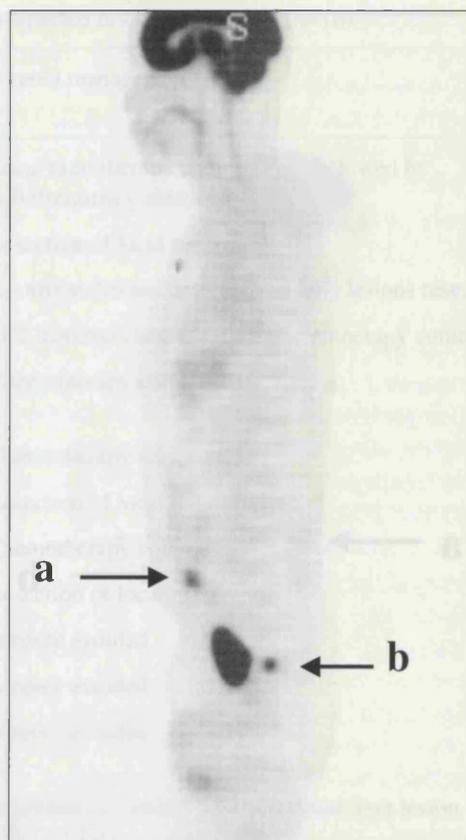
Coronal FDG-PET study in a patient who previously underwent anterior resection of a rectal cancer. The tumour marker CEA began to rise 2 years postoperatively although the patient remained asymptomatic and no recurrence was identified on conventional imaging. FDG-PET detected a recurrent lesion (a) in the pelvis. This was successfully resected
